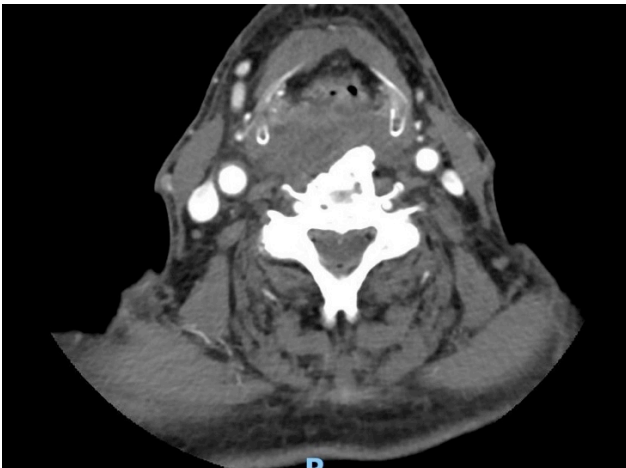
CT Scan of the neck
